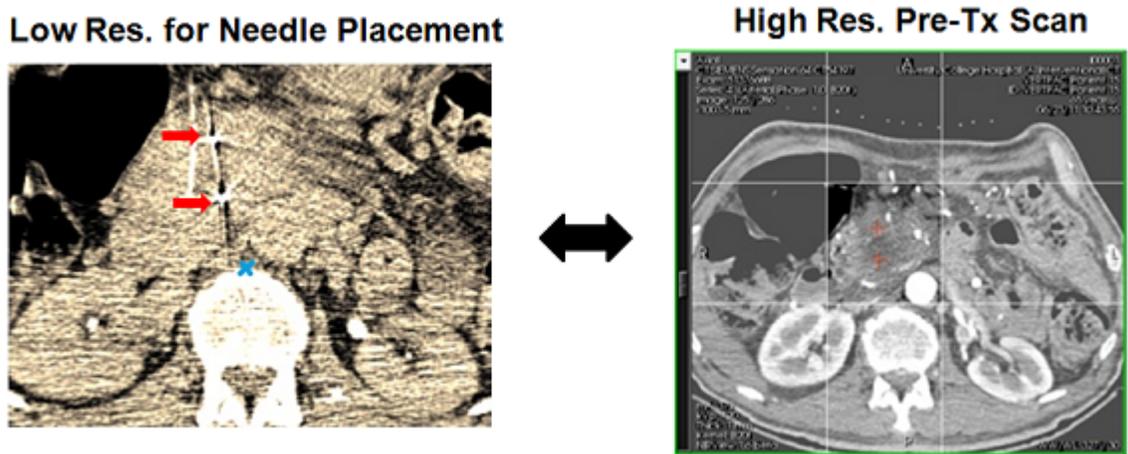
Fiducial locations present on the low resolution needle placement scans (left, shown by red arrows) are registered onto the high resolution contrast CT pre-treatment scans (right, shown by red + marks). The red markers indicate the fiducial locations, and the blue marker is the tip of the spinal vertebra reference location used in image transformation.
